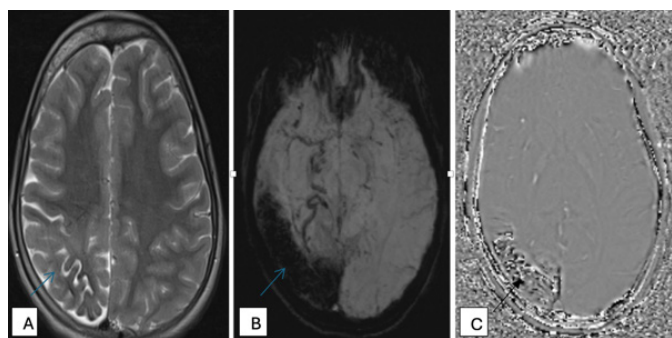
(A–C): Brain MRI showing a venous anomaly in the right parieto occipital cortical and extensive area with hyposignal in axial T2-weighted and SWI (blue arrow in A and B), and corresponding signal dropout in C (black arrow), related to calcifications.
